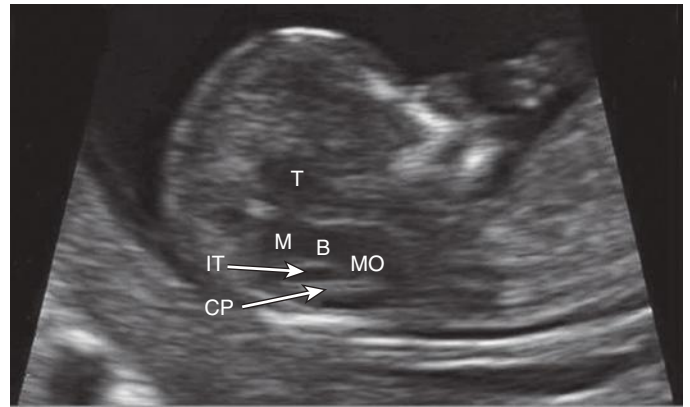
Ultrasound image of a normal fetal central nervous system in the midsagittal plane at 12 weeks' gestation. The thalamus (T), midbrain (M), brainstem (B), medulla oblongata (MO), and choroid plexus (CP) of the fourth ventricle are noted. The normal intracranial translucency (IT) of the fourth ventricle is present.
